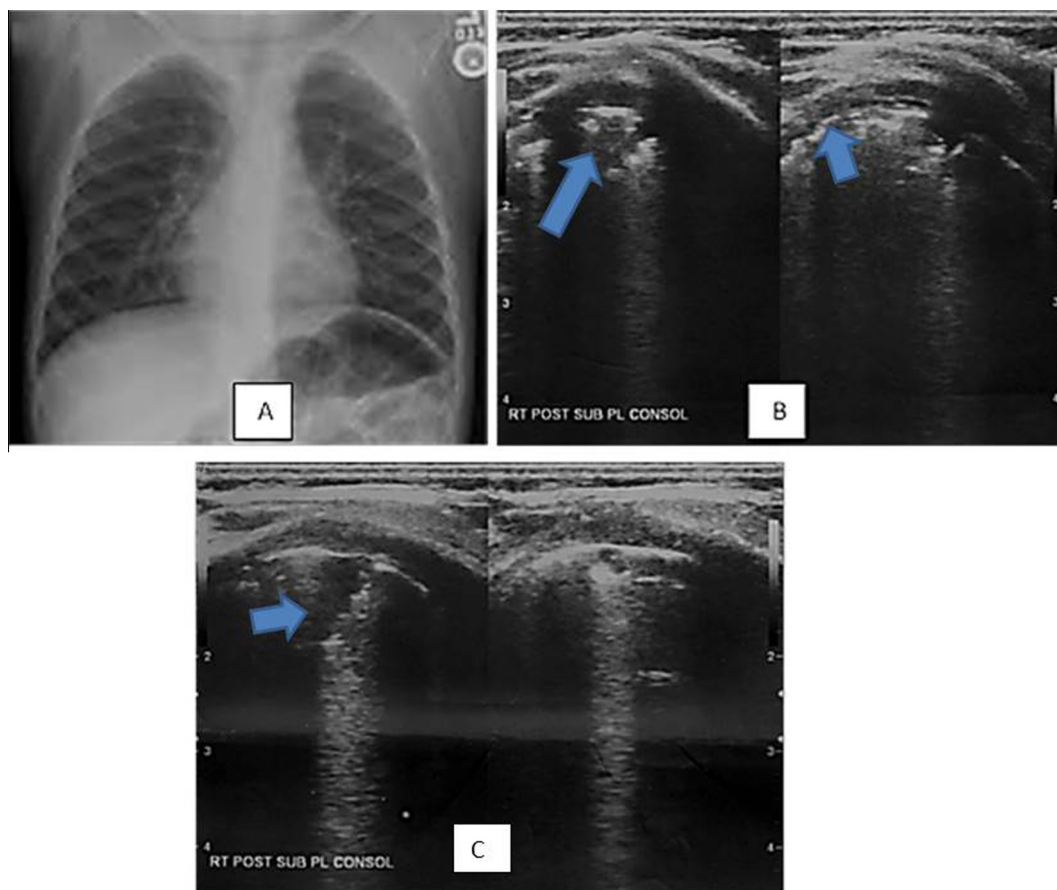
A – Chest X-ray of 3 months-old infant with severe bronchiolitis revealed increased lung markings. B – Lung ultrasound of the same patient revealed posterior sub-pleural area of consolidation on the right lung (long arrow) with pleural line thickening and irregularity (short arrow). C – Showed posterior sub-pleural consolidation of the right lung (arrow) with isolated B-line.
